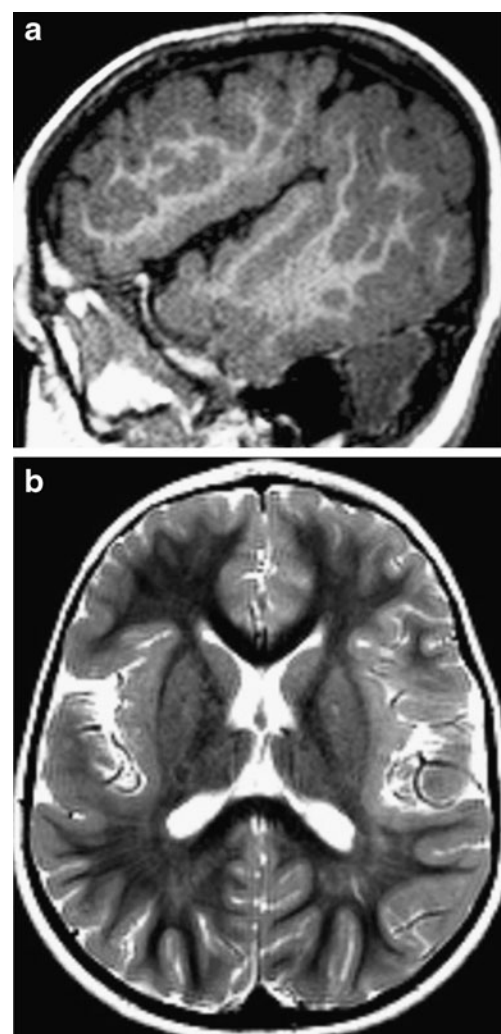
Grade 3 perisylvian PMG. Parasagittal T1-weighted images (a) and axial T2-weighted images (b) show polymicrogyria limited to the insulae and operculae
